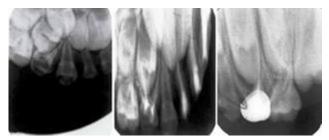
Preoperative and Postoperative intraoral periapical radiograph of 54
